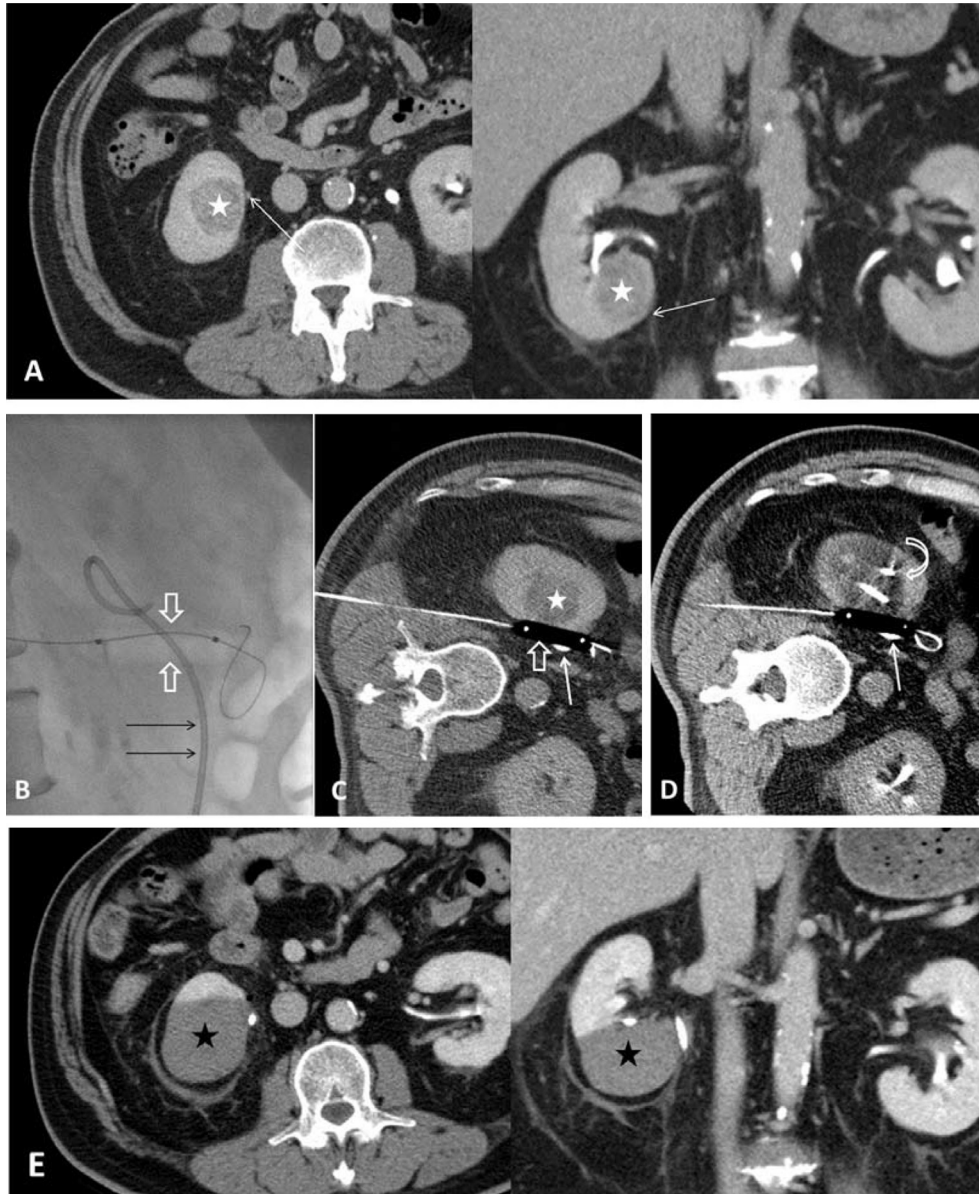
The 62-year-old male patient had a renal tumor at the lower pole of the right kidney. (A) Axial (left) and coronal (right) postcontrast computed tomography (CT) images show a renal tumor at the lower pole of the right kidney (white stars in A and C) contacting the ureter (thin white arrows). (B) Retrograde double J ureteral stent placement was prescribed prior to the procedure (black arrows in B and thin white arrows in C and D). During the procedure, a balloon catheter was inserted between the tumor and double J ureteral stent under fluoroscopic guidance, and inflated with air (open arrows in B and C). (C) Intraprocedural contrast enhanced CT scan demonstrates that the inflated balloon displaced the ureter from the tumor. (D) Monitoring CT scan during freezing demonstrates the ice ball as a low-density area surrounding the cryoprobes (curved arrow) and covering the tumor. (E) Two days after the procedure, axial (left) and coronal (right) postcontrast CT images show nonenhancing area at the lower pole of right kidney (black stars), indicating postcryoablation change. Note that the collecting system is not dilated.
